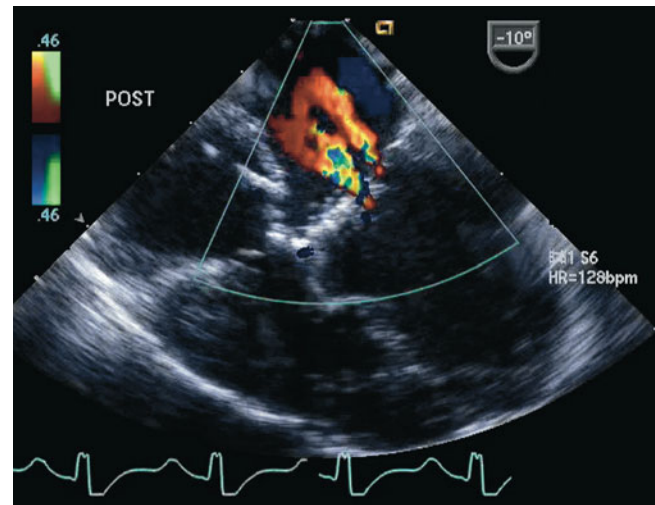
Postoperative transesophageal echocardiogram following repair of a complete atrioventricular septal defect. Color Doppler interrogation demonstrates two small jets of left atrioventricular valve regurgitation. The jet closest to the interatrial septum represents regurgitation across a residual cleft
